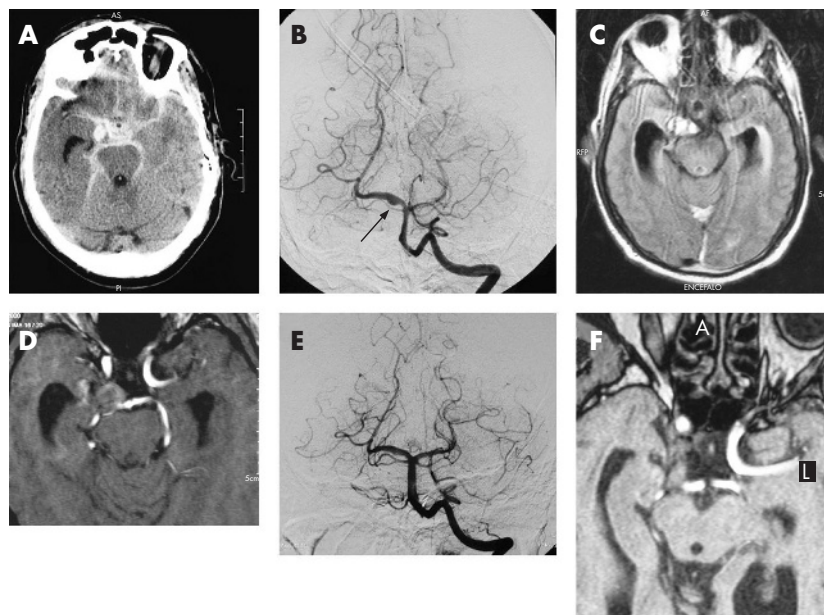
Computed tomography scan at admission showing extensive subarachnoid haemorrhage (SAH) (A). Digital subtraction angiography (DSA; anteroposterior projection) showing a fusiform dilatation of the P1–P2 segment of the right posterior cerebral artery (PCA) with a focal "blister" (arrow) (B). Twenty days later, axial fluid-attenuated inversion recovery magnetic resonance (FLAIR MR) image (C) and axial T1-weighted source image of three-dimensional time-of-flight magnetic resonance angiography (3D TOF MRA) (D) show an area of abnormal signal intensity in the right portion of the ambiens cistern surrounding the P1–P2 segment of the right PCA, consistent with intramural haematoma in the subacute phase. DSA (E) and source image of 3D TOF MRA (F) 4 months after SAH showing a near normalisation of the right PCA calibre without focal blister (E) and a decrease in the size of the intramural haematoma (F).
